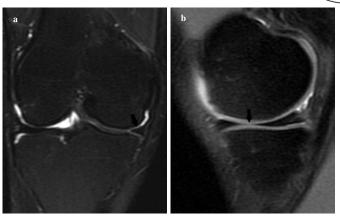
a, b: Coronal T2W Fat Sat 1.5 T MRI image shows the normal triangle shape of the medial meniscus and no signal at the tip of the free edge of medial meniscus body (arrow, a) Sagittal PDW Fat Sat 1.5 T MRI image shows a very small signal at the free edge of the medial meniscus body in only a single section (arrow, b).
